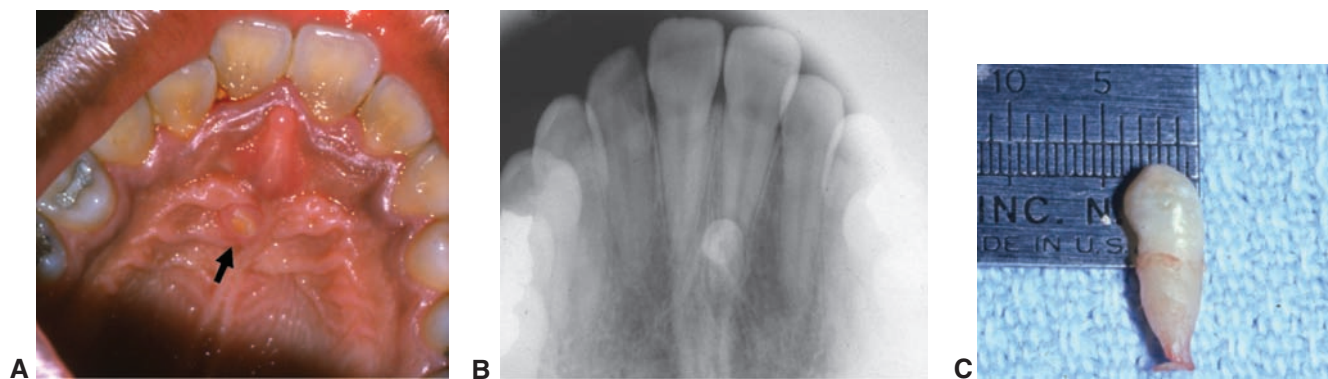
Accessory tooth. A. Clinical appearance of diminutive tooth in the rugae area of the hard palate. B. Occlusal radiograph of the accessory tooth seen in A. C. Extracted tooth as seen in A is only 4 mm in width.
